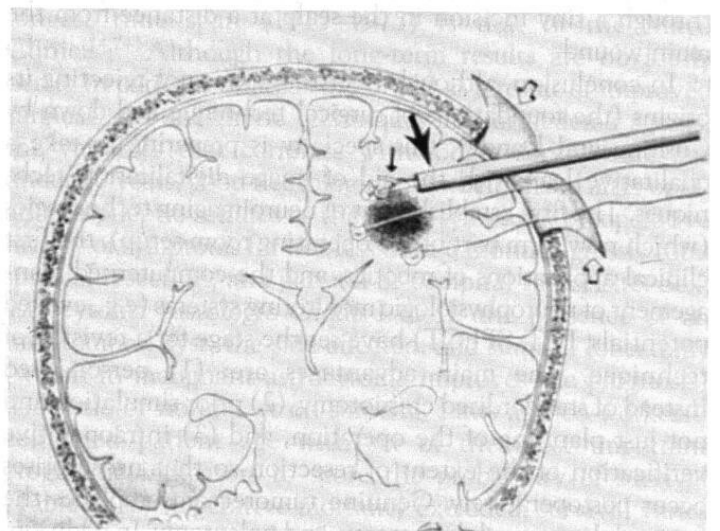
Artificial coordinates method(s): stereomarkers. (From Hassenbusch SJ, Anderson JS, Pillay PK: Brain tumor resection aided with markers placed using stereotaxis guided by magnetic resonance imaging and computed tomography. *Neurosurgery* 28:801-806, 1991.)
